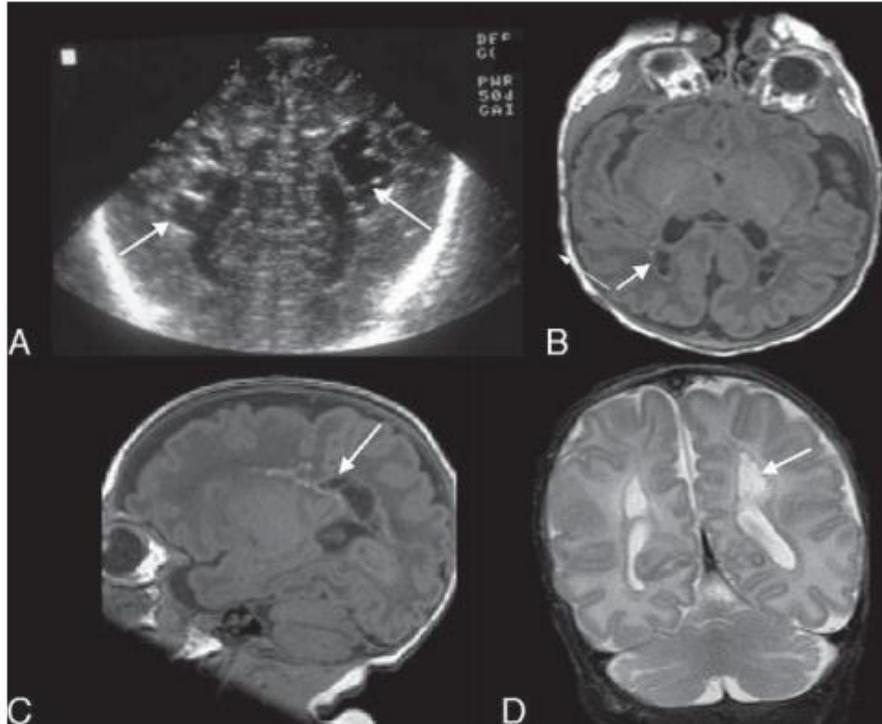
Early sign of periventricular leukomalacia. (A) US shows periventricular echolucencies (arrows), one of the earliest signs of periventricular leukomalacia. (B,C) On T1-weighted MRI sequences, these are seen posteriorly in the peritrigonal area and are lined by small focal regions of T1 shortening in keeping with haemorrhage (arrows).
